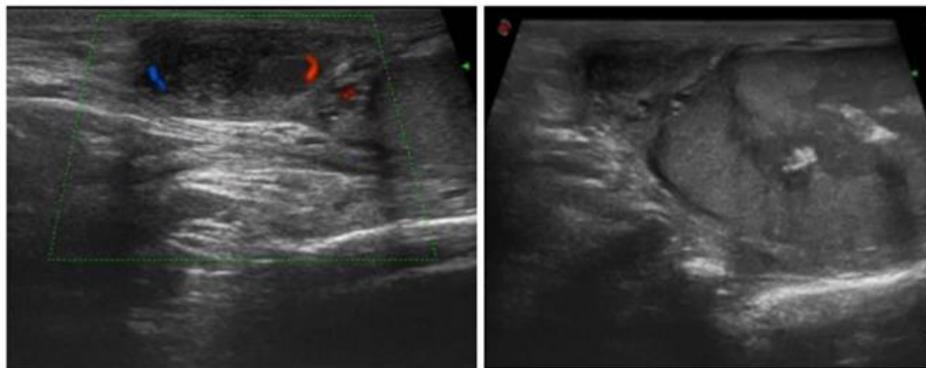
Testicular ultrasound showed a hypoechoic area with macro calcifications. The epididymal head is enlarged with normal vascularization on color Doppler
